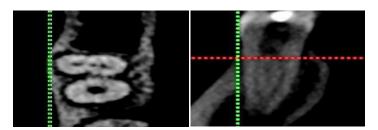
A photograph showing the presence of MMC in axial view in CBCT scan.
